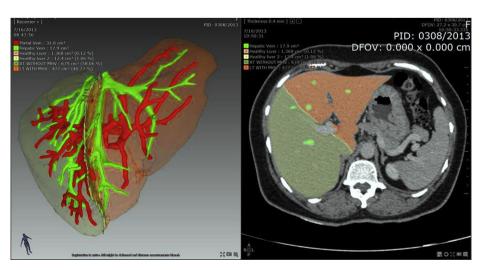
Preoperative 3D CT volumetry being done to decide the plane of resection.
